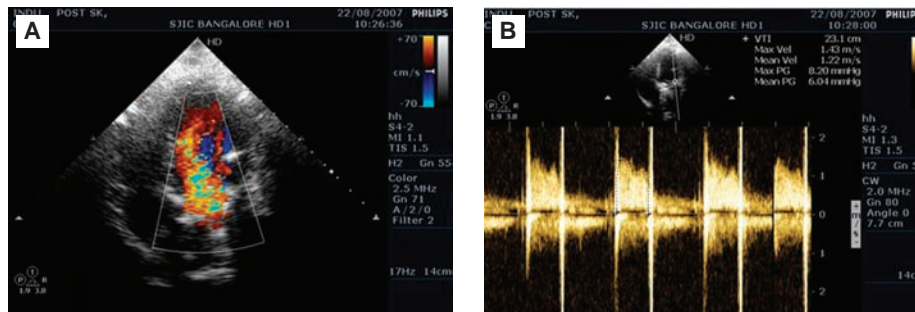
(A) Post-thrombolysis reduced turbulence across mitral valve prosthesis. (B) Post-thrombolysis continuous wave Doppler recording across prosthetic mitral valve showing significantly reduced gradient (mean gradient 6 mmHg).
